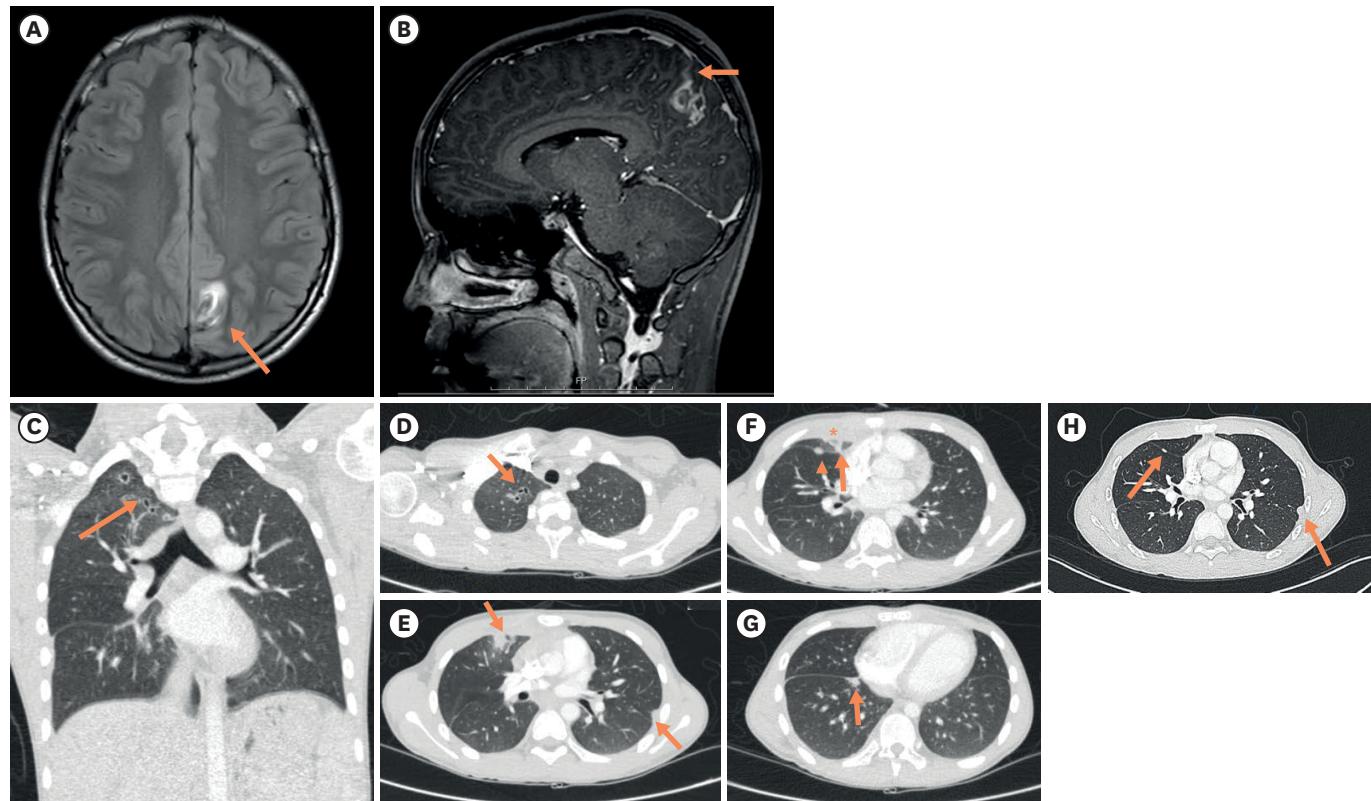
Radiologic findings of pleuropulmonary and cerebral paragonimiasis in a 12-year-old male presenting with severe headache. (A) Axial T2-weighted FLAIR brain MRI shows a hyperintense lesion with internal hemorrhage in the left parietal lobe (arrow). (B) Contrast-enhanced sagittal T1-weighted MRI demonstrates adjacent localized leptomeningeal enhancement (arrow), suggestive of localized meningoencephalitis. (C, D) Chest CT in lung window reveals a serpiginous tubular structure in the right upper lobe apex, consistent with a worm migration tract, seen on both coronal (C) and axial (D) images. (E) Multiple subpleural consolidations are noted in the right middle and left lower lobes (arrows). (F) Diffuse pleural thickening in the right anterior thorax (*) with a subpleural nodule at the right minor fissure (arrowhead) and linear opacities in the right upper lobe anterior segment (arrow). (G) Additional subpleural nodule along the right major fissure (arrow). (H) Follow-up chest CT obtained 8 months later demonstrates interval improvement of previous pulmonary lesions, with residual subpleural consolidation in the left upper lobe (arrow) and decreased subpleural nodule along the right minor fissure (arrow). FLAIR, fluid-attenuated inversion recovery; MRI, magnetic resonance imaging; CT, computed tomography.
